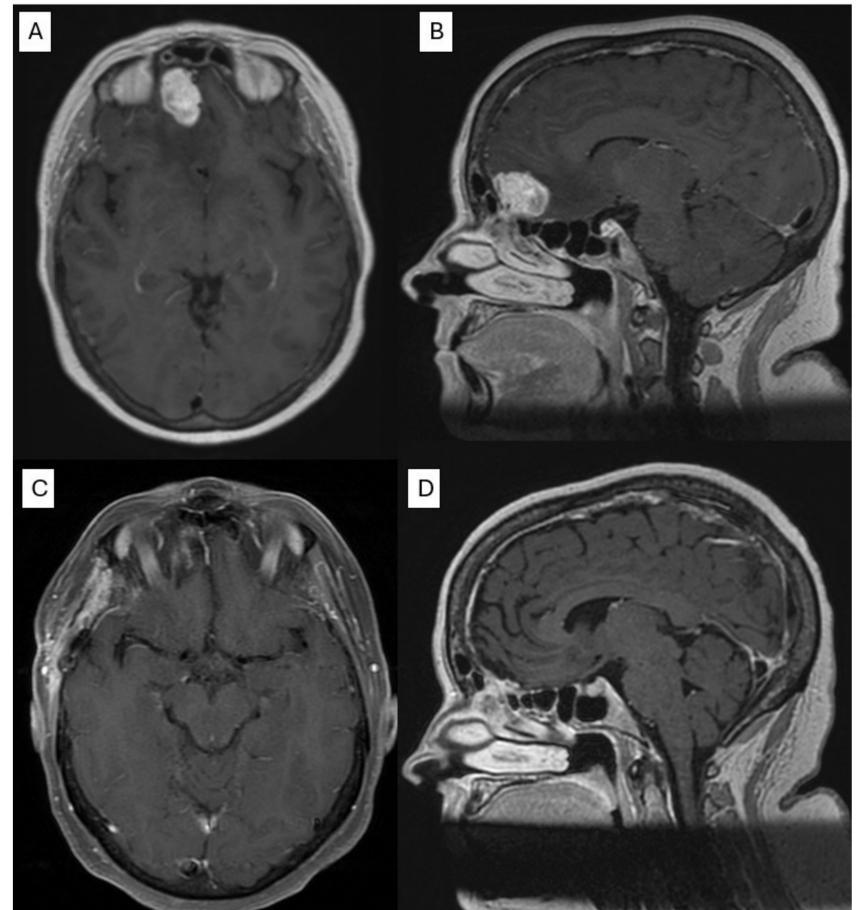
Preoperative (A&B) and postoperative (C&D) contrasted MRI scans of a PMT mimicking an olfactory groove meningioma.
